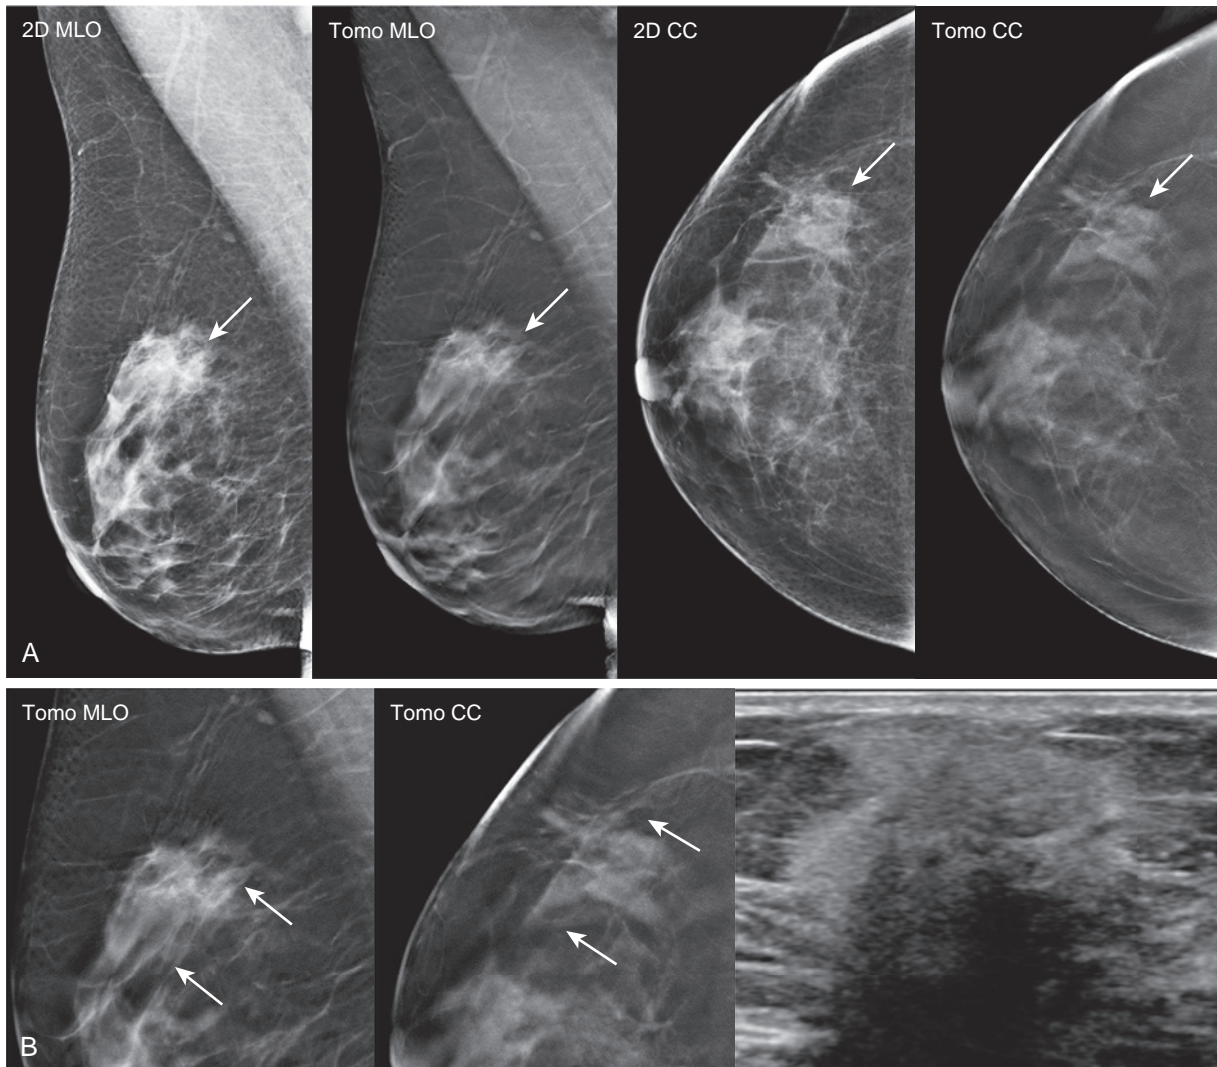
Architectural distortion seen on only one CC slice. (A) Screening mammogram in a 56-year-old woman reveals a developing asymmetry in the right upper outer quadrant (arrows). (B) Close-up tomosynthesis views reveal an associated AD. Although the spicules are obvious on the MLO view, they are more subtle on the CC view and only seen on a single tomosynthesis slice (arrows). Targeted ultrasound shows a corresponding mixed echogenic irregular 2.5 cm mass with posterior acoustic shadowing. Ultrasound-guided core needle biopsy and excision = IDC, moderately differentiated, ER/PR+. Her2-, 1/2SLN.
